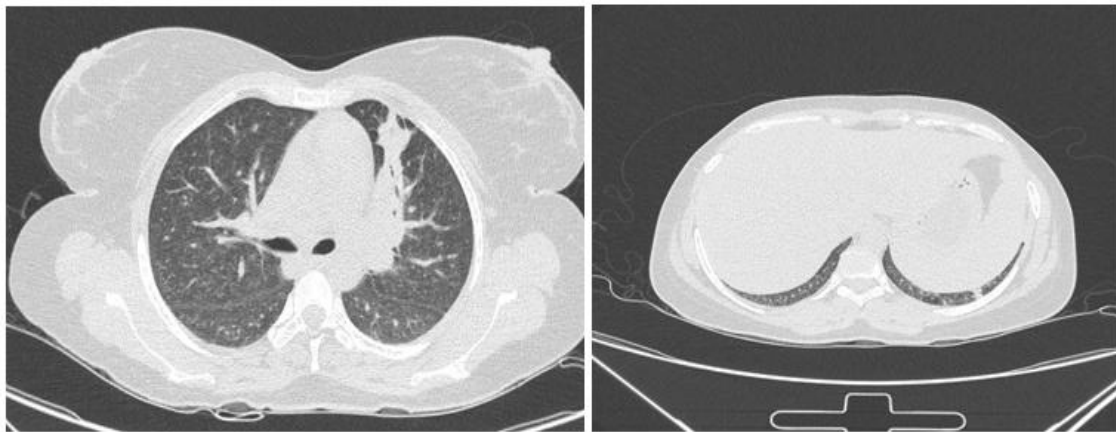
High Resolution Computed Tomography CHEST shows subsegmental consolidation in anterior segment of both upper lobes and mild hepatosplenomegaly
